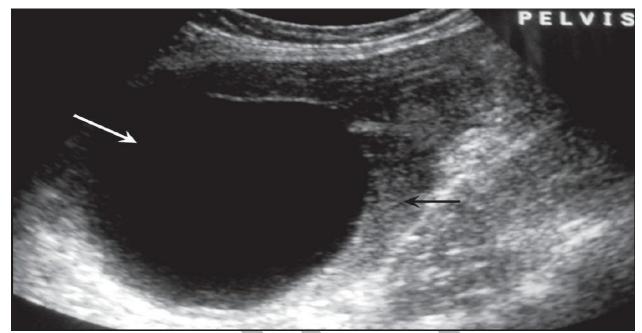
Ultrasound imaging findings suggestive of? Endometrioma, Hydrometra
